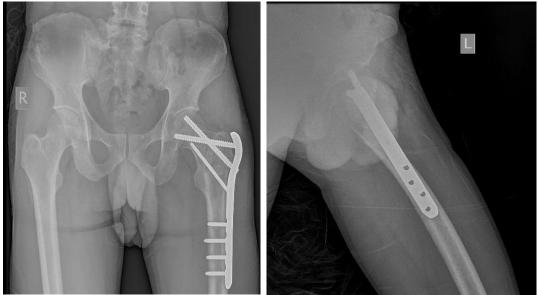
no: 6 Immediate Post-operative Hip and Pelvic X-ray (AP and Lateral)
